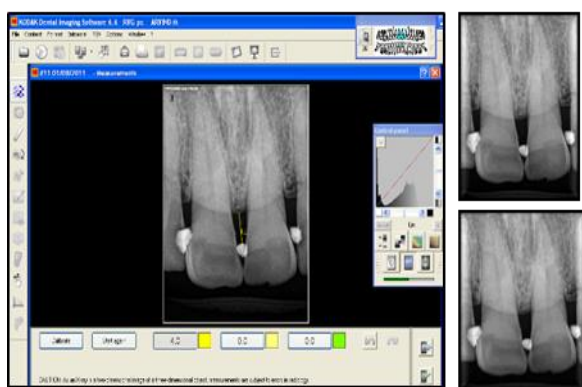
Radiographic measurement of Papilla Height and Bone Crest-Contact Point on RVG.
